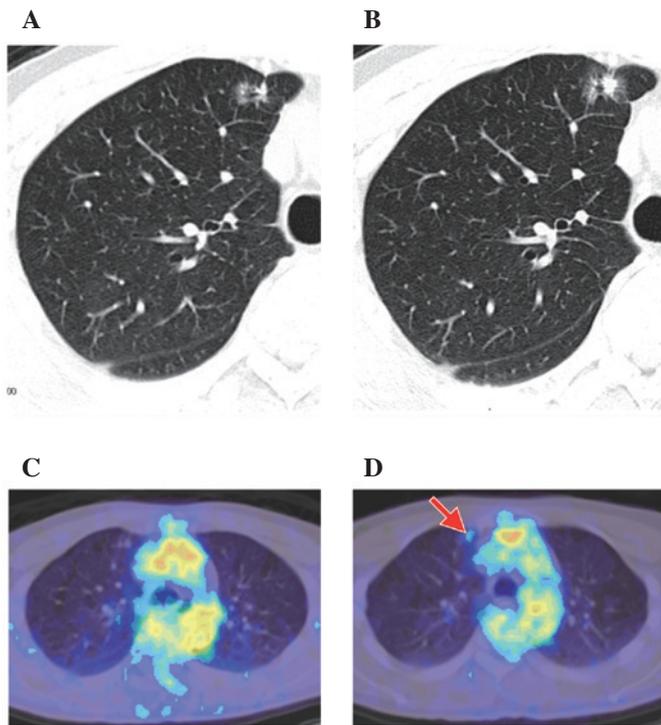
(A) A CT scan revealed a ground-glass opacity (GGO) lesion (10 mm) in the upper lobe of the right lung of a patient in September 2005. (B) A year later, the CT scan revealed an abnormal shadow of a larger size (15 mm) in the upper lobe of the right lung and GGO with a small solid area. (C) PET/CT revealed no abnormal F-18 2'-deoxy-2-fluoro-D-glucose (FDG) uptake in the GGO lesion in September 2005. (D) PET/CT revealed abnormal FDG uptake in the GGO lesion with SUVmax 1.2 (arrow) one year later.
